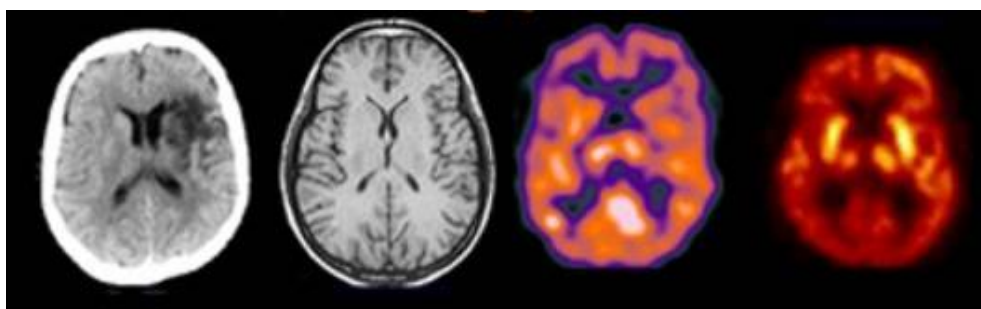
Human brain slices with different imaging modalities. From left to right: CT, MRI, SPECT and PET (Wright 2010)
